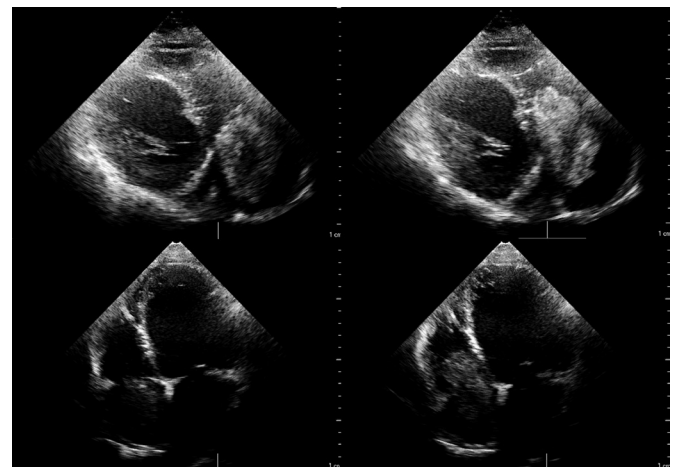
Transthoracic echocardiographic visualization of the tumor.
